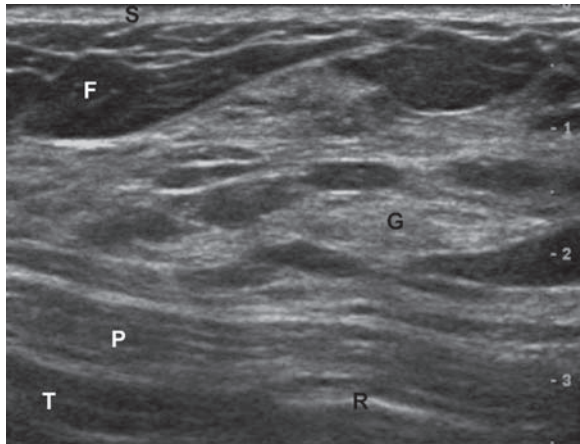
Normal breast anatomy on ultrasound. The skin (*S*) is represented by horizontal echogenic lines. Below this there is a layer of hypoechoic subcutaneous fat (*F*). This is followed by alternating bands of fibroglandular tissue (*G*). The retromammary fat lies on the chest wall. The pectoral muscle (*P*), ribs (*R*) and thoracic cavity (*T*) are deep to the retromammary fat
